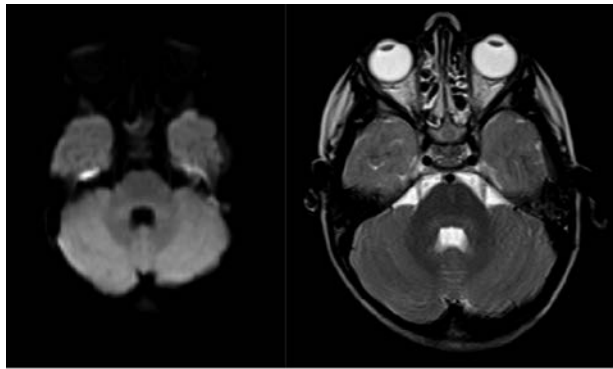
T2-weighted and diffusion weighted images show no pathologic intensity on pons.
